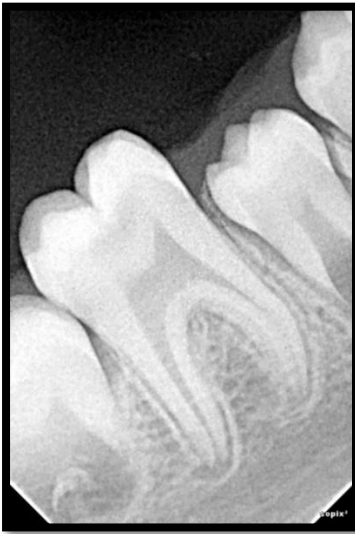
Post Extraction Radiograph
